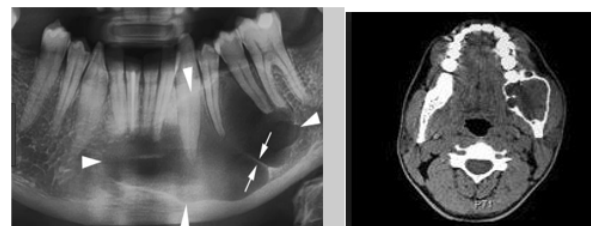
Xray and CT scan showing well defined expansile lesion involving left ramus of mandible with few septations in it
